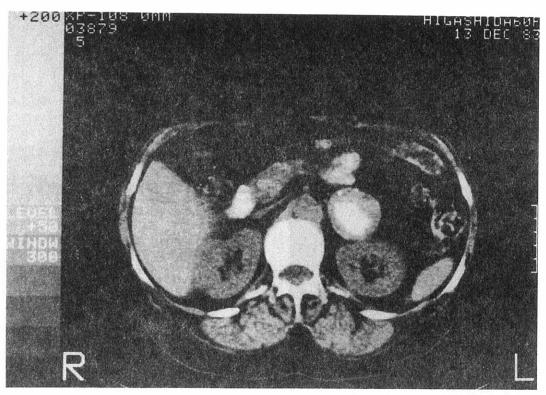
CT of the left retroperitoneal region demonstrated a well-demarcated mass (5cm), containing massive calcification centrally.
